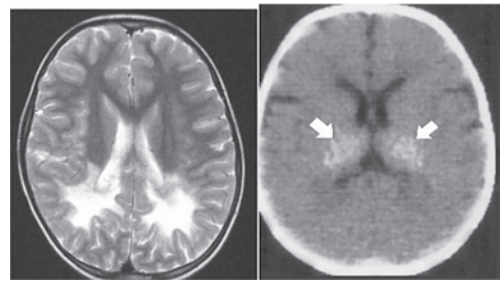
Krabbe disease Axial T2 MR showing peri ventricular white matter hyperintensity b. CT brain showing hyperdense thalami
